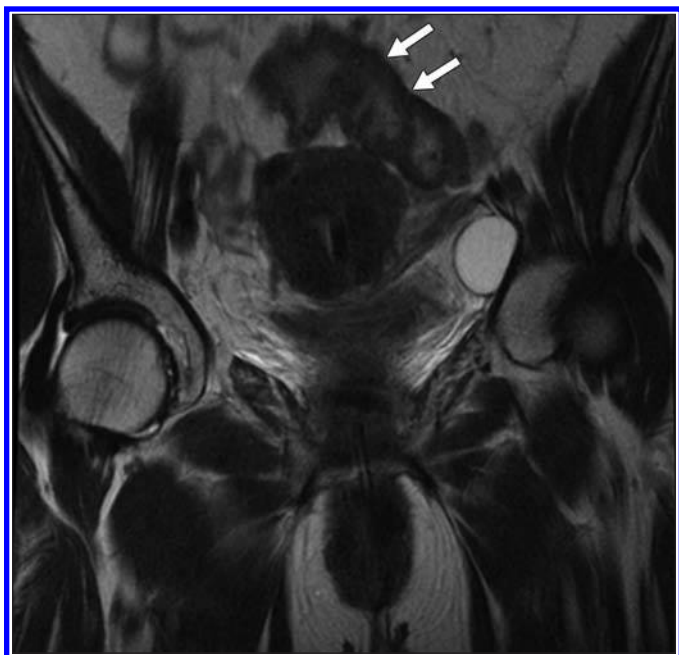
44-year-old woman with cervical cancer. Sagittal T2-weighted MR image of pelvis shows diffuse sigmoid colitis (*arrows*) in patient undergoing intracavitary brachytherapy. Degree of mucosal edema is suggestive of radiation colitis and consistent with patient's symptoms of abdominal cramping and diarrhea.
